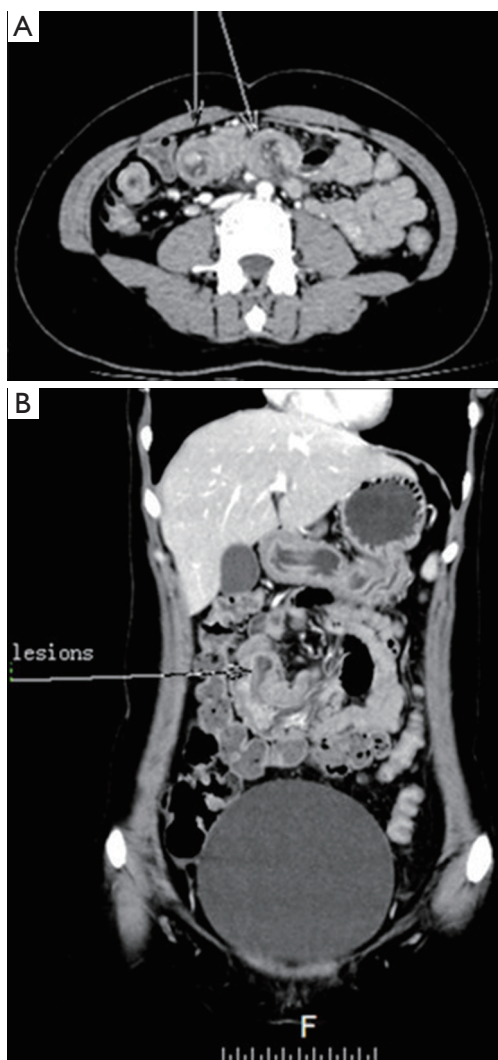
CT scan. (A) (plain): focus on different levels of performance, arrow points to “a concentric circle syndrome”, partial wall thickening. The vascular and ring enhancement in the outer tube is enhanced, and the enhanced scanning is layered enhancing; (B) (coronal position): there is a tumor in the intestinal tract, its diameter is about 2 cm. Note: white arrow refers to the lesion.
